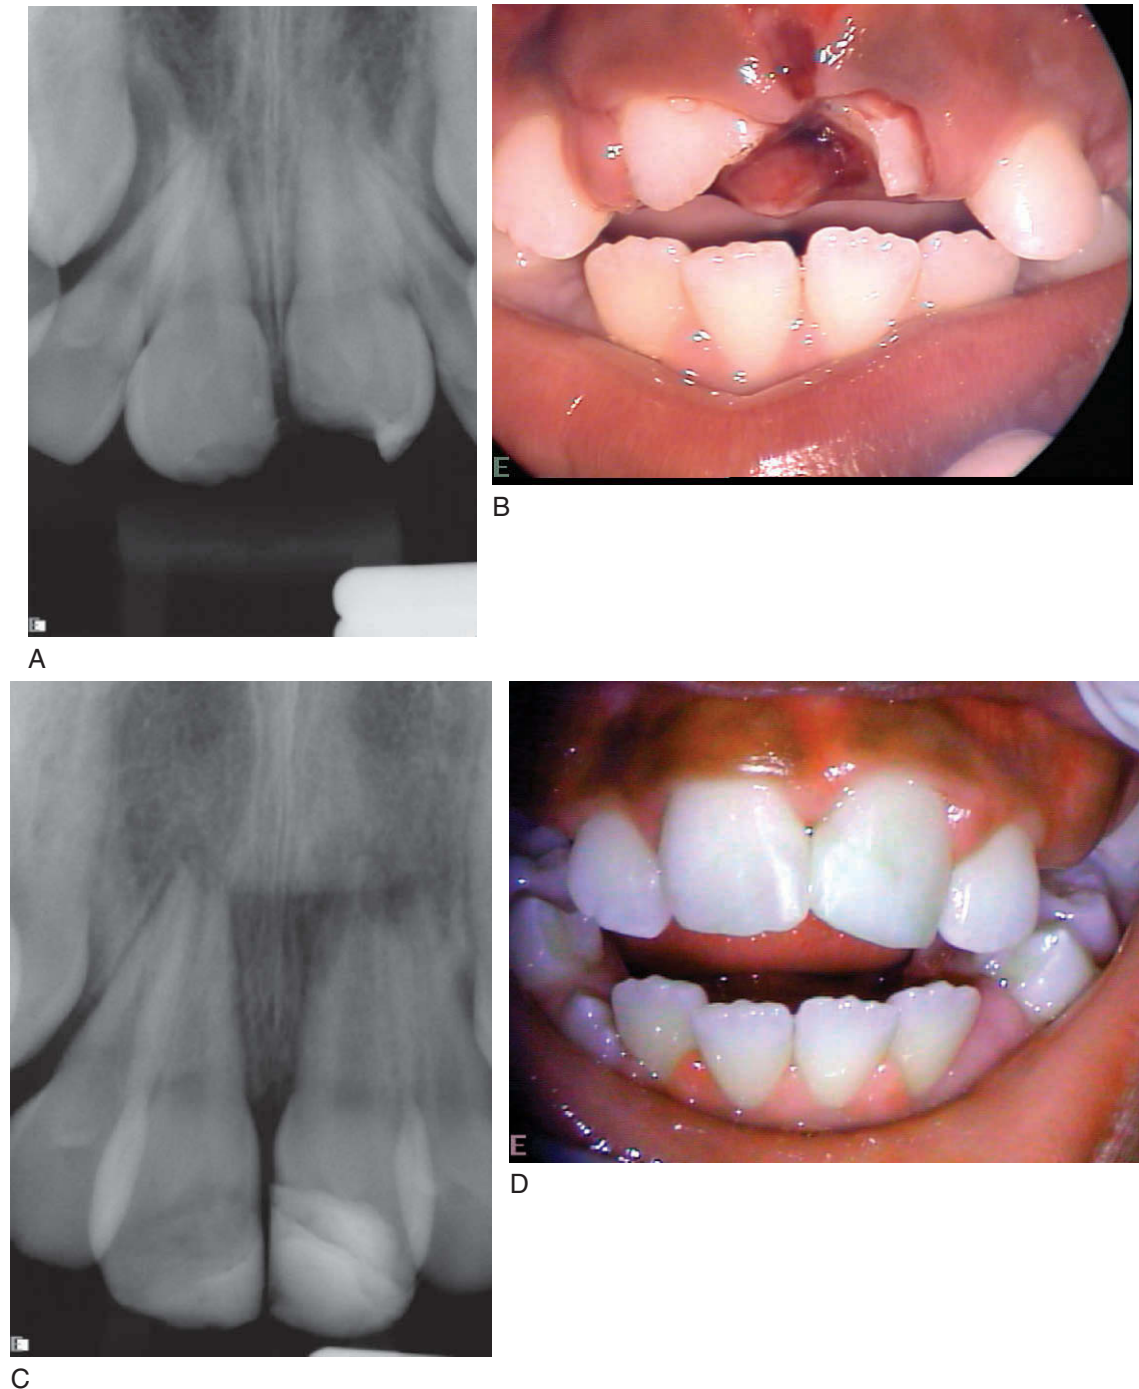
Intrusive luxation of 9-year old male with immature tooth development. A, Radiograph exposed 3 hours after intrusive luxation of teeth #8 and 9. Note uncomplicated crown fractures. B, Clinical photograph 3 hours after trauma. C, Radiograph 4 months after trauma with spontaneous re-eruption, but with apical root resorption of the left central insisor. D, Clinical photograph 4 months after trauma with teeth restored.
